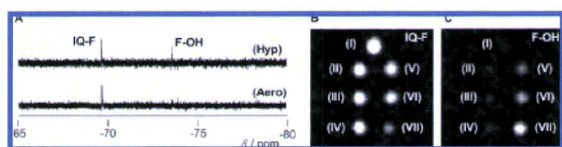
(A) One-electron reduction of IQ-F in A549 cells. A549 cells were incubated with IQ-F (355 μ M) for 12 h under hypoxic (Hyp) or aerobic (Aero) conditions. The medium obtained from the reaction sample was subjected to an ^{19}F NMR study. (B,C) ^{19}F MR images of IQ-F incubated with cell lysate of A549 for 0 (I), 6 (II and V), 12 (III and VI), and 24 h (IV and VII) under aerobic (II, III, and IV) or hypoxic (V, VI, and VII) conditions: (B) IQ-F signal selected image; (C) F-OH signal selected image.
